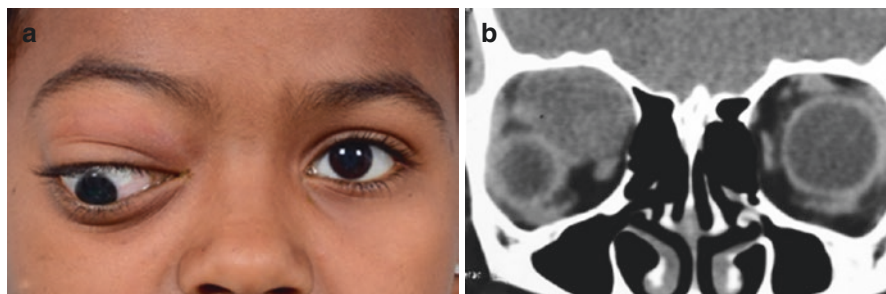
Orbital rhabdomyosarcoma. (a) A 10-year-old female with right hypoglobus. (b) Coronal CT shows a large right superomedial orbital lesion displacing the globe downward and outward
